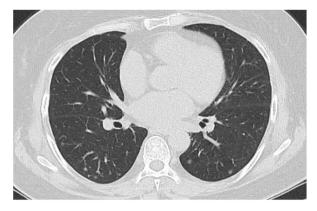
Chest CT follow-up at 3 months, Diffuse multifocal nodules without significant change.
